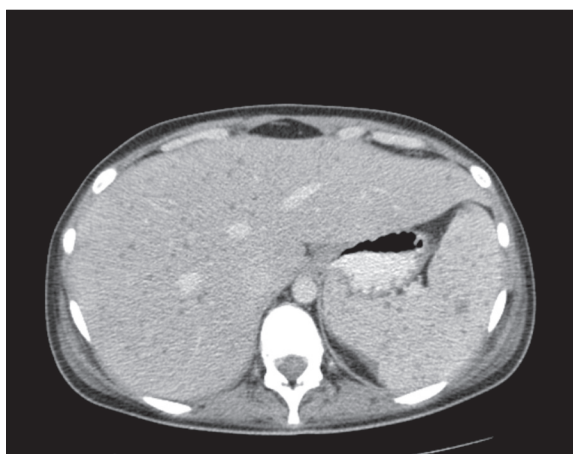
Patient JM age 17 with diagnosis of acute lymphoblastic leukemia during chemotherapy. CT examination with i.v. application of contrast shows multiple, small mycosal abscesses of liver and spleen.
